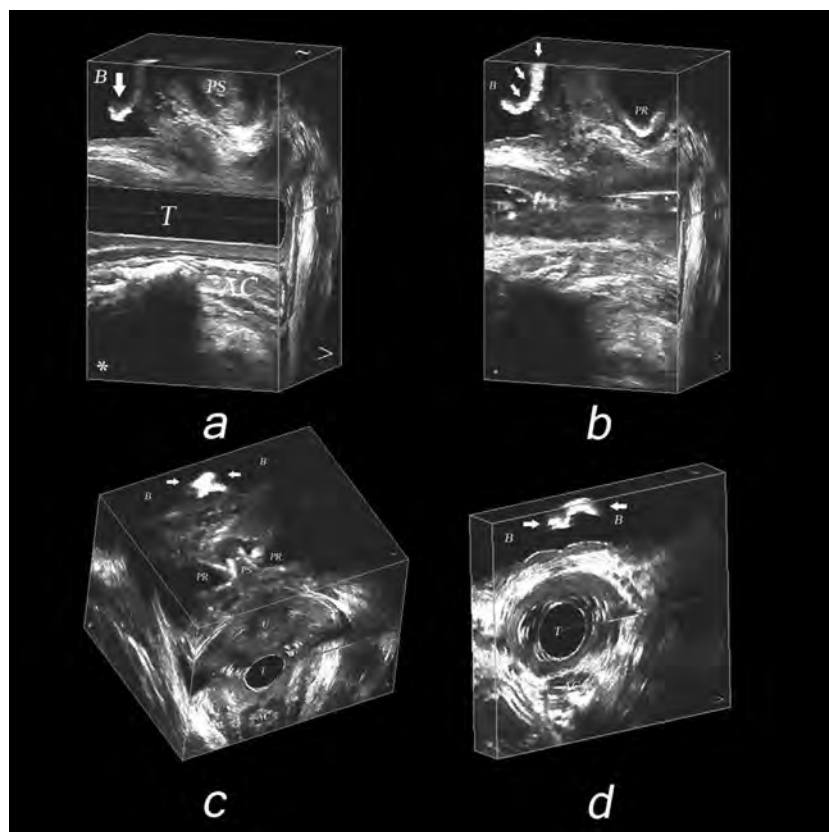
The sagittal (a and b), coronal (c), and axial (d) views of three dimensional ultrasound volume demonstrating a sling in the bladder (arrows). B indicates bladder; T, transducer; AC, anal canal; PS, pubic symphysis; and PR, pubic rami.
